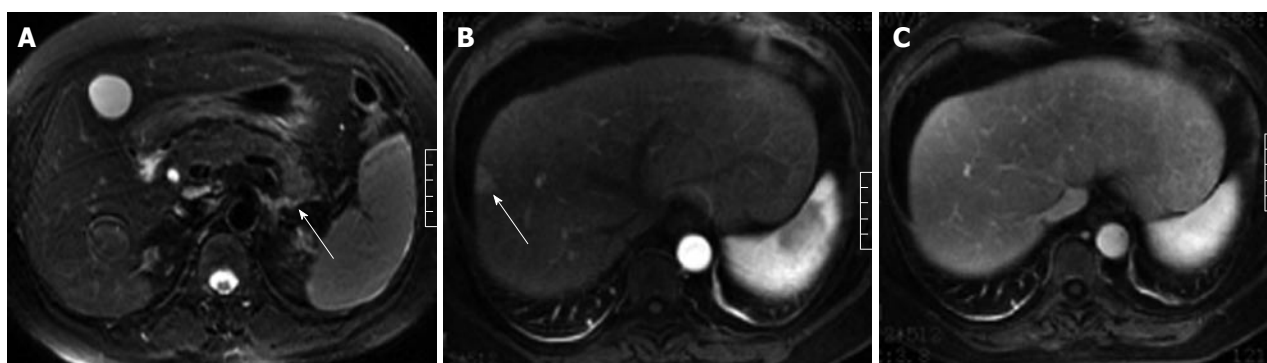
A 50-year-old woman with acute pancreatitis without gallbladder and common bile duct abnormalities. Fast recovery fast spin-echo T2-weighted image (A) shows peri-pancreatic strand hyperintensity signal (arrow). Wedge-shaped hepatic abnormal perfusion (arrow) is found in the right lobe of liver on the artery phase (B) and returns to normal on the venous phase images (C).
